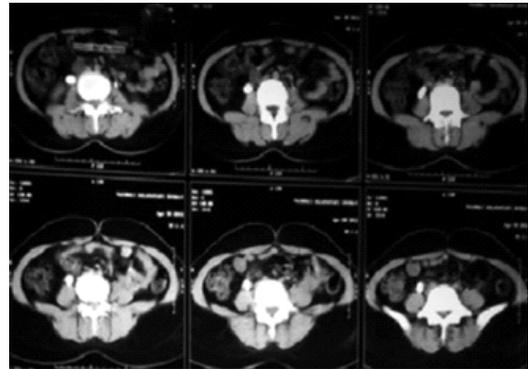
Computed tomography kidney, ureter, bladder of patient with right hydroureter and right ureterovaginal fistula
